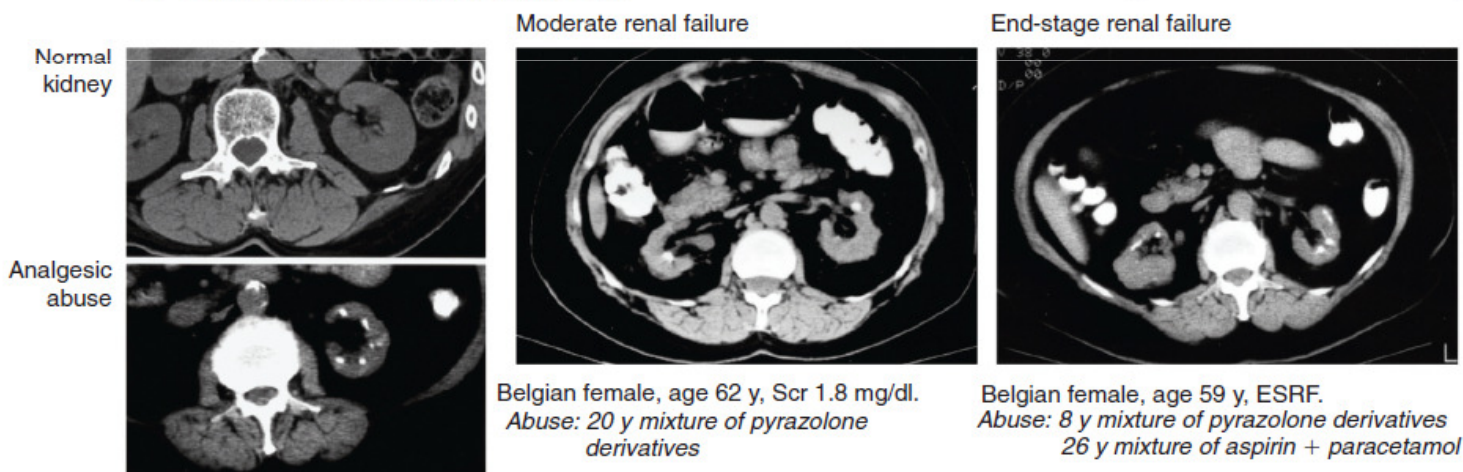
Renal imaging criteria of analgesic nephropathy (AN) as observed in a postmortem kidney and in computed tomography (CT) scans without contrast material. These criteria include a decreased renal size, bumpy contours, and papillary calcifications. RA, Renal artery; RV, renal vein; SP, spine. (Adapted from De Broe ME, Elseviers MM: Analgesic nephropathy. *N Engl J Med* 338:446-452, 1998.)
